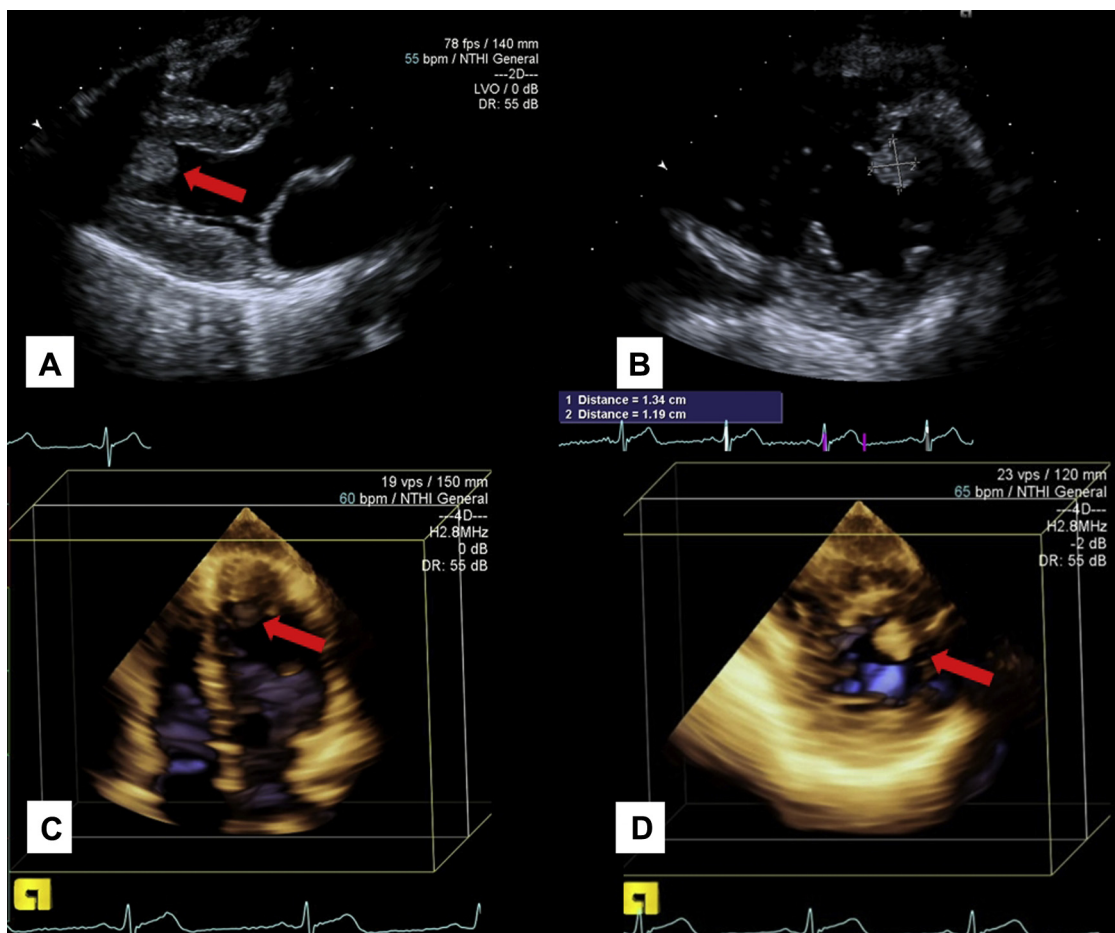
Transthoracic echocardiography demonstrates an oval, homogeneous, mobile mass originated from the lower midpart of the interventricular wall. Parasternal long (A), short (B) axis view, 3-dimensional echocardiography (C and D).
